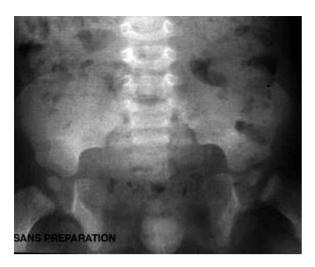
AP radiograph of the pelvic cavity showing widening of the pubic symphysis in a girl with vesical exstrophy
